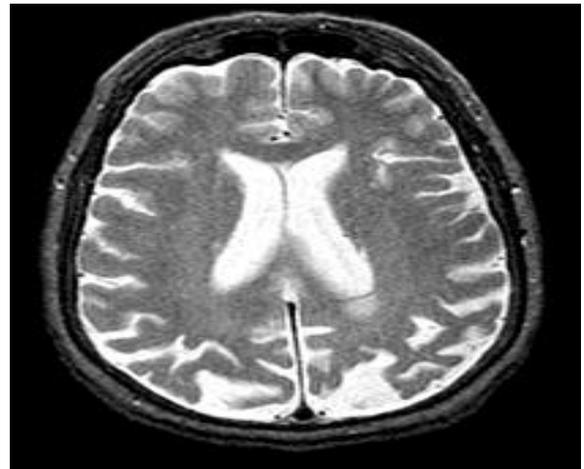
At this decreased level, there is also noticeable extreme widening of the intraparietal sulci, and shrinkage of the inferior parietal lobules, while the frontal gyri remain relatively unaffected. Also take note of the dilated lateral ventricles. Alzheimer's disease with functional MRI
